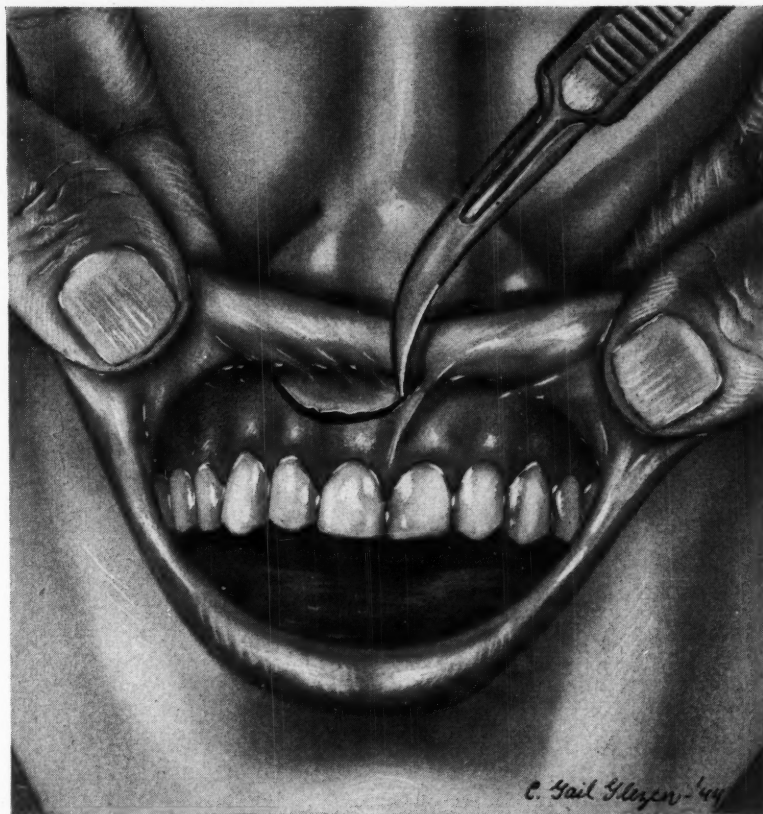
The incision for the open method of removing a periapical cyst or granuloma following the electric desiccation treatment in the root canal.
